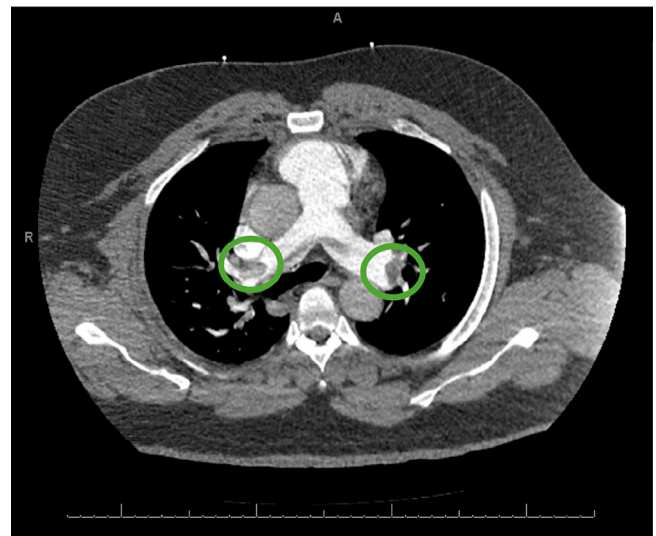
Computed tomography pulmonary angiography demonstrates the presence of significant bilateral and saddle pulmonary embolism.
